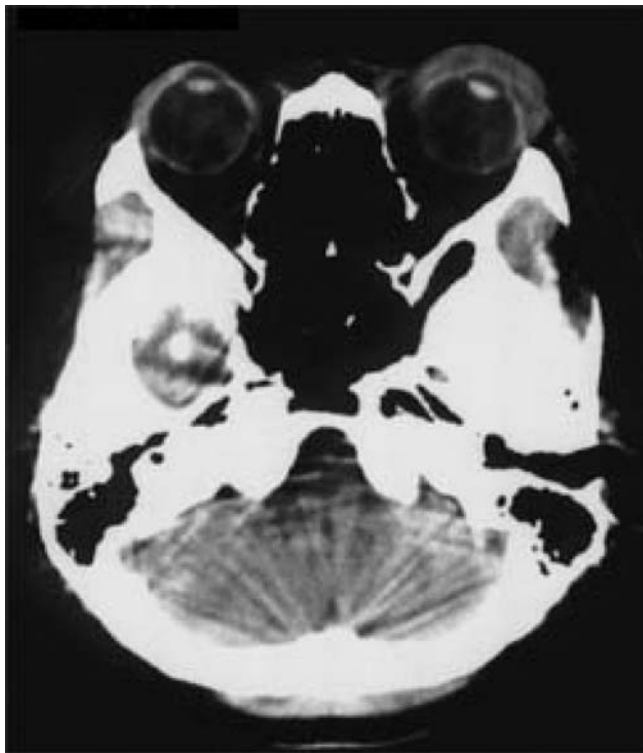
Computed tomographic image of the head showing swelling of the left eyelid. The axis of the left eyeball is slightly shifted toward the ear, suggesting the paralysis of cranial nerves. No mass lesions oppressing the nerves are seen in the brain
